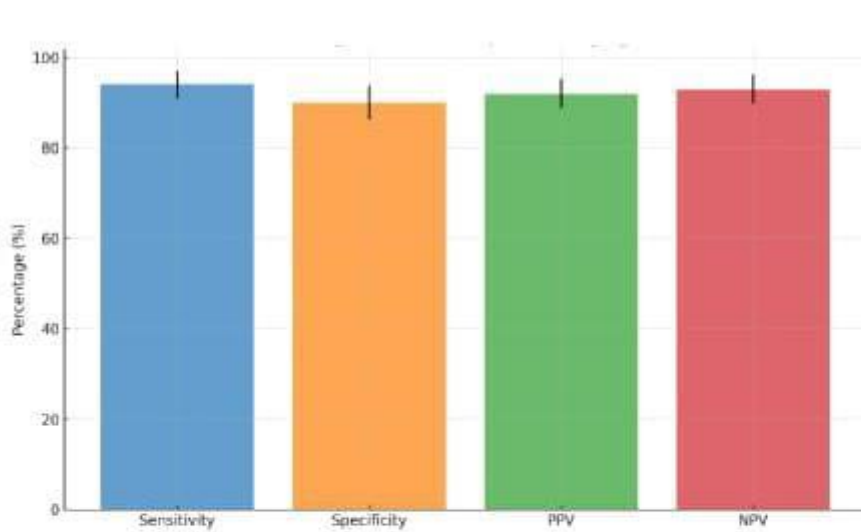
Figure No:2. Diagnostic Accuracy -CT Imaging
